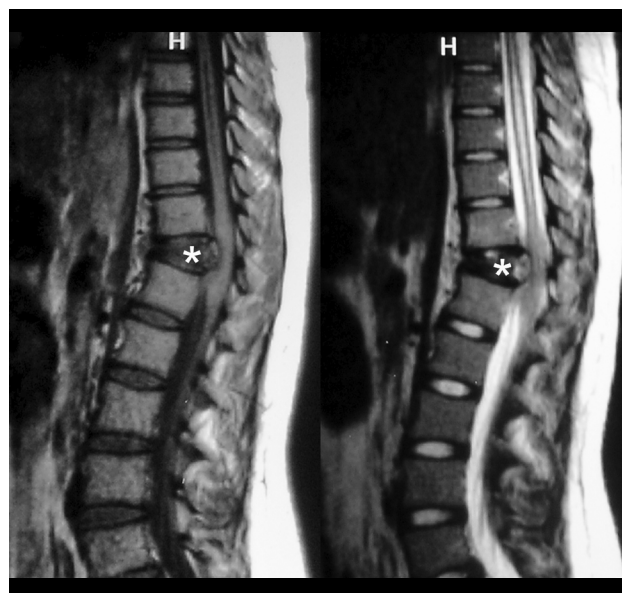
MRI of the thoracolumbar spine in a 15-year-old girl with vertebral osteosarcoma. Sagittal T1WI (left) and T2WI (right) demonstrating marked collapse of the T12 vertebral body, which shows heterogeneous signal intensity in the marrow; areas of hypointensity on both sequences reflect mineralized tumor matrix (asterisks). Note the posterior wall bulging compressing the ventral spinal cord, with dilation of the central canal above that level.
